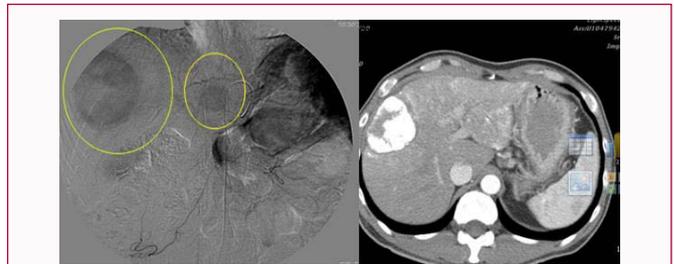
The transarterial chemo-embolization (TACE) was done (left) and follow-up abdominal CT revealed hyperdense mass after TACE (right).
